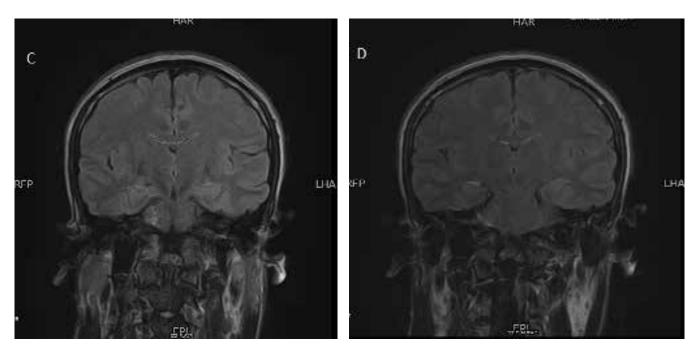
Coronal FLAIR (fig. C) and post-contrast (fig. D) showed interval resolution of previously identified gyral thickening involving the bilateral frontal lobes.
